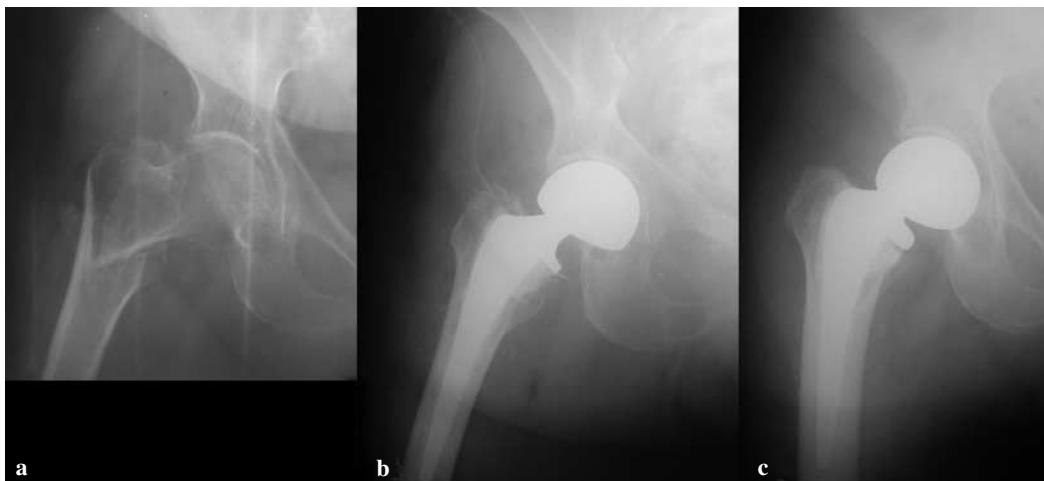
A2.2 intertrochanteric fracture in an 83-year-old patient with body mineral density (BMD) = $-2.7 T$ score. a Preoperative radiograph. b Postoperative roentgenogram after bipolar hip replacement. c Radiographic result at the 3-year follow-up
